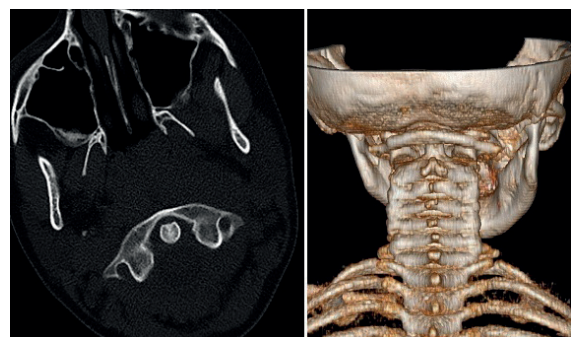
It is observed that the atlanto-axial distance is normal and subluxation is non-existent in the axial section (a) and reformat 3D (b) cervical CT images.
